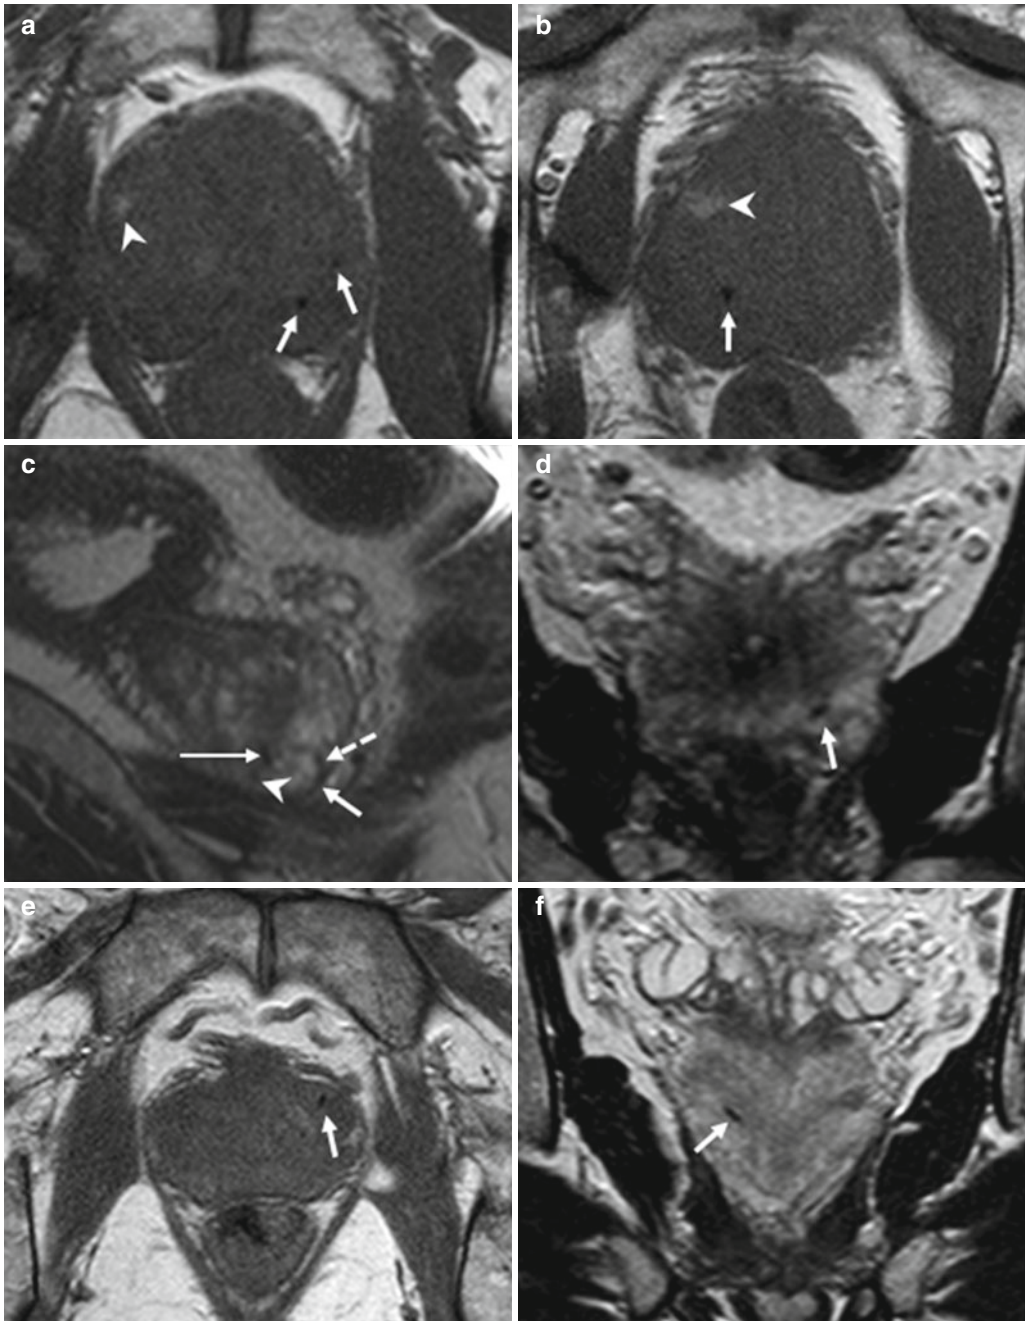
(a–f) 62 years old, PSA 7.8 ng/ml, diagnosis of prostate tumor 3 months ago (Gleason 6, 3+3), candidate for radiotherapy. (a, b) axial T1-weighted (TR: 500; TE: 10) sequences. (c, d) sagittal (TR: 4006; TE: 100) (c) and coronal (TR: 4013; TE: 100) (d) T2-weighted sequences, respectively. The subject underwent placement of gold fiducial marker seeds that are used as a fixed standard of reference during radiation treatment. The markers are inserted by performing a transrectal ultrasound: three markers are inserted through a needle which is passed through the ultrasound probe. The markers correspond to the very
